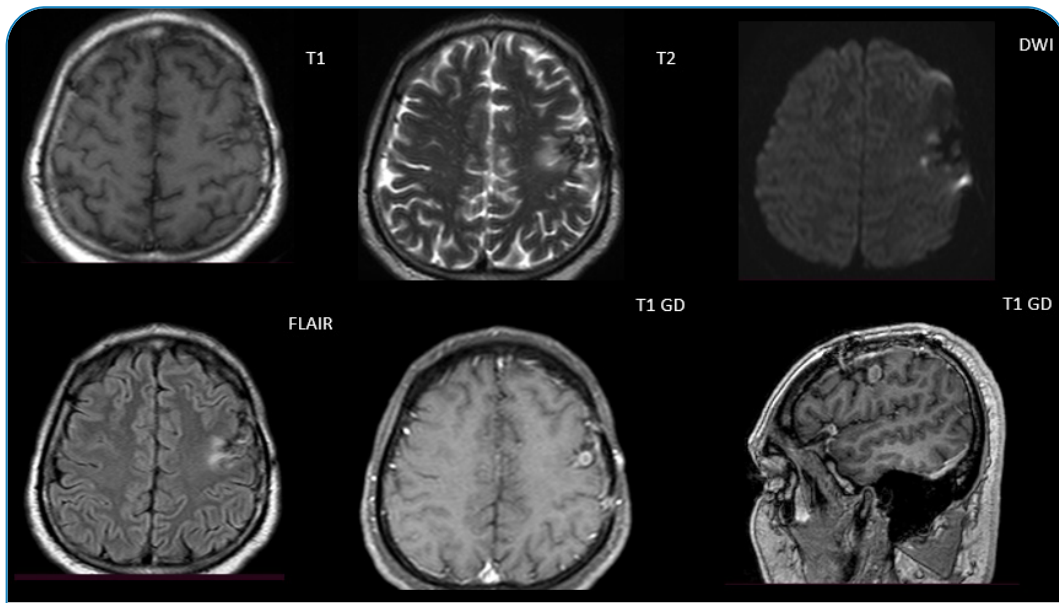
After the second month of amoebic brain abscess treatment. Left to right, top to bottom, brain MRI sequences of axial slices in unenhanced T1, T2, diffusion, FLAIR, T1 with contrast, and sagittal T1 with contrast, respectively. Radiological improvement after treatment demonstrated by blue arrows.
